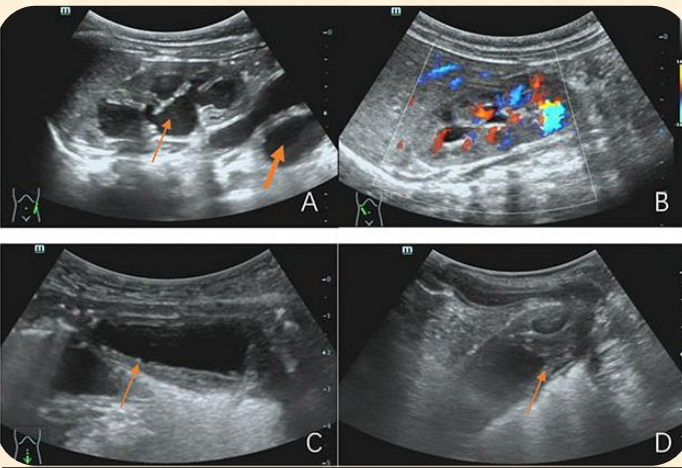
Ultrasound characteristics of posterior urethral valve in children: Case 1, male, 1 day, prenatal ultrasound diagnosed bilateral hydronephrosis and bilateral ureteral dilatation.
